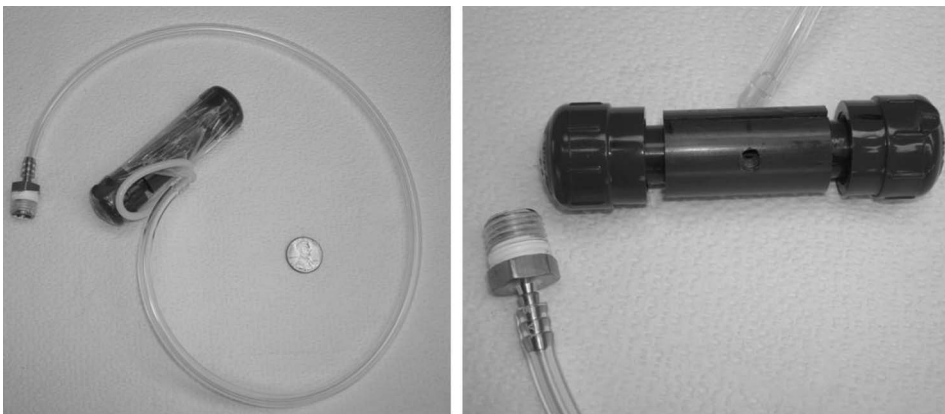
First MRI-safe genital vibrator. Fins are spun by compressed air to displace the counter weight and produce vibration.
